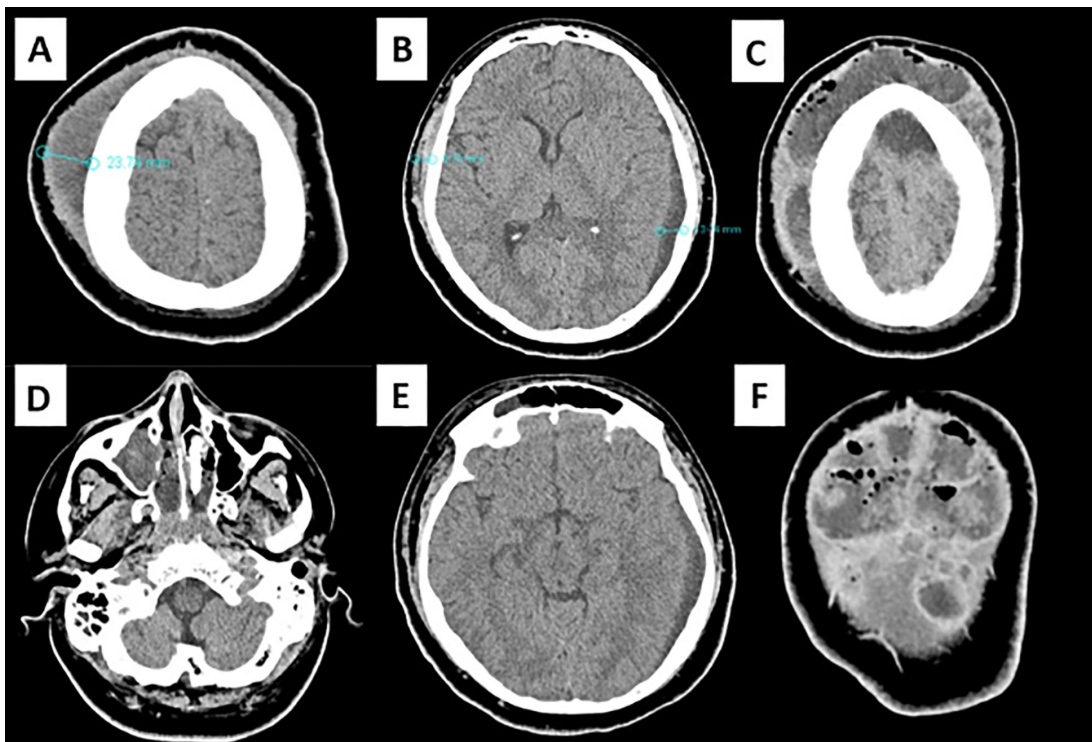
Brain CT: A) Soft tissue enlargement (23.74 mm) along the high convexity, with gaseous foci; B) Another extradural collection with intermingled gaseous foci and a thickness of 1.1 cm next to the upper aspect of the sickle; C) Simultaneously extra and intracranial abscess without bone involvement; D and E) Thick content inside the frontal and maxillary sinuses on the right side; F) Soft tissue enlargement with multiple purulent abscesses and gaseous foci.
